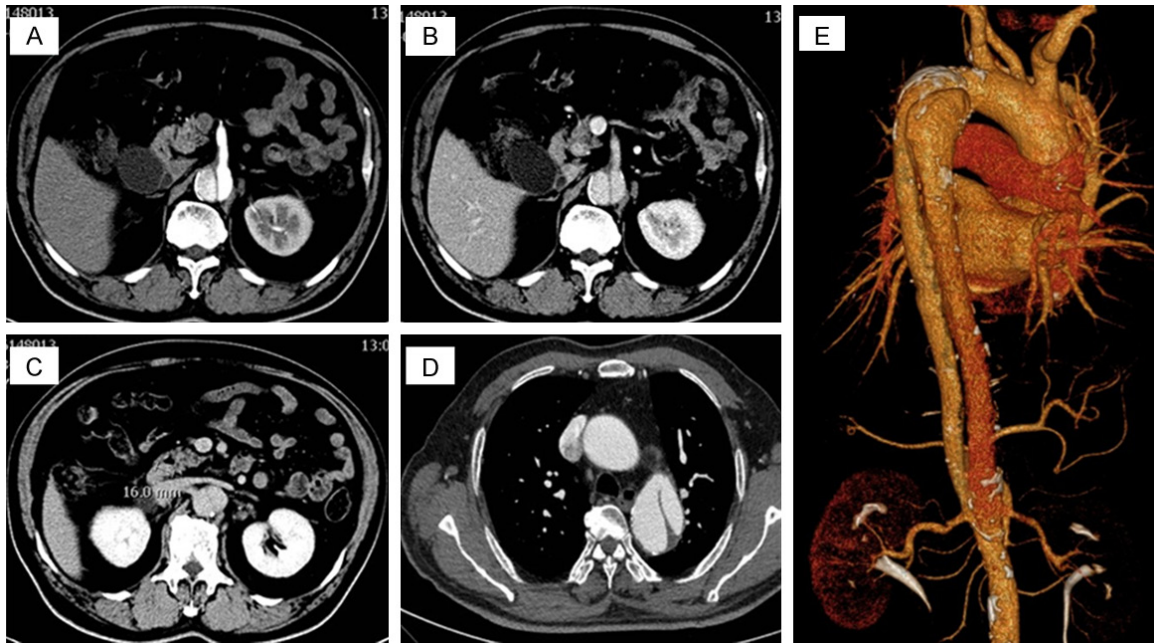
Abdominal enhanced CT and CTA. Aortic dissection is indicated in (A (arterial phase) and B (venous phase)). (C (balanced phase)) shows cholangiocarcinoma. (D) indicates the location of the entry point, and (E) shows the whole aortic dissection.
